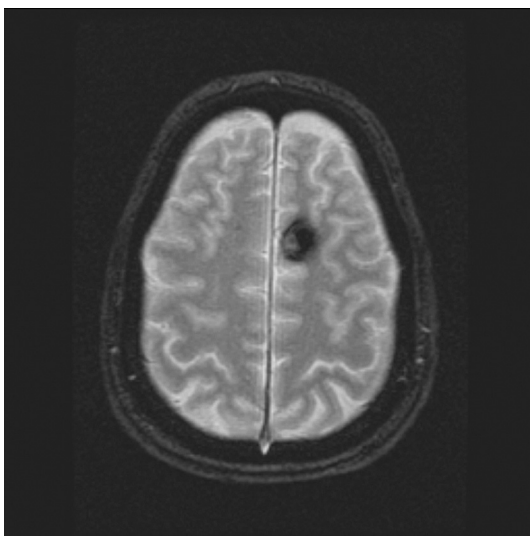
Cavernous malformation. A 45-year-old man presented with personality changes and headaches. A susceptibility-weighted MRI shows a left frontal cavernous malformation.
